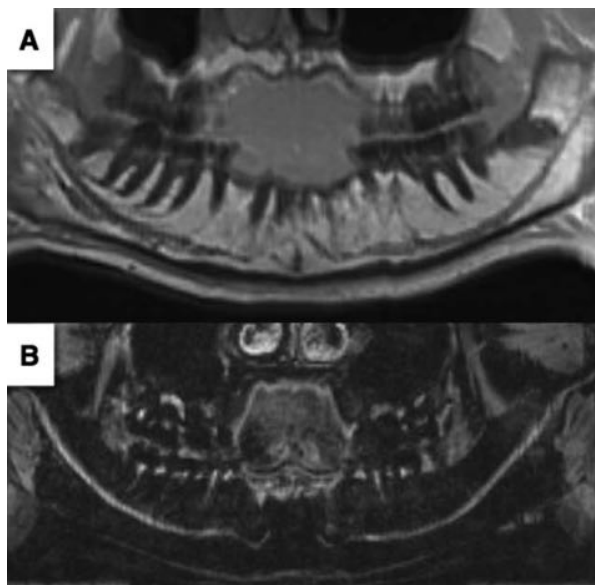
MR neurographic orthopantomogram. Curved planes reconstructed from 3D-PETRA (A) and 3D-PSIF (B) following the anatomical orientation of mandibular canal/nerve.
